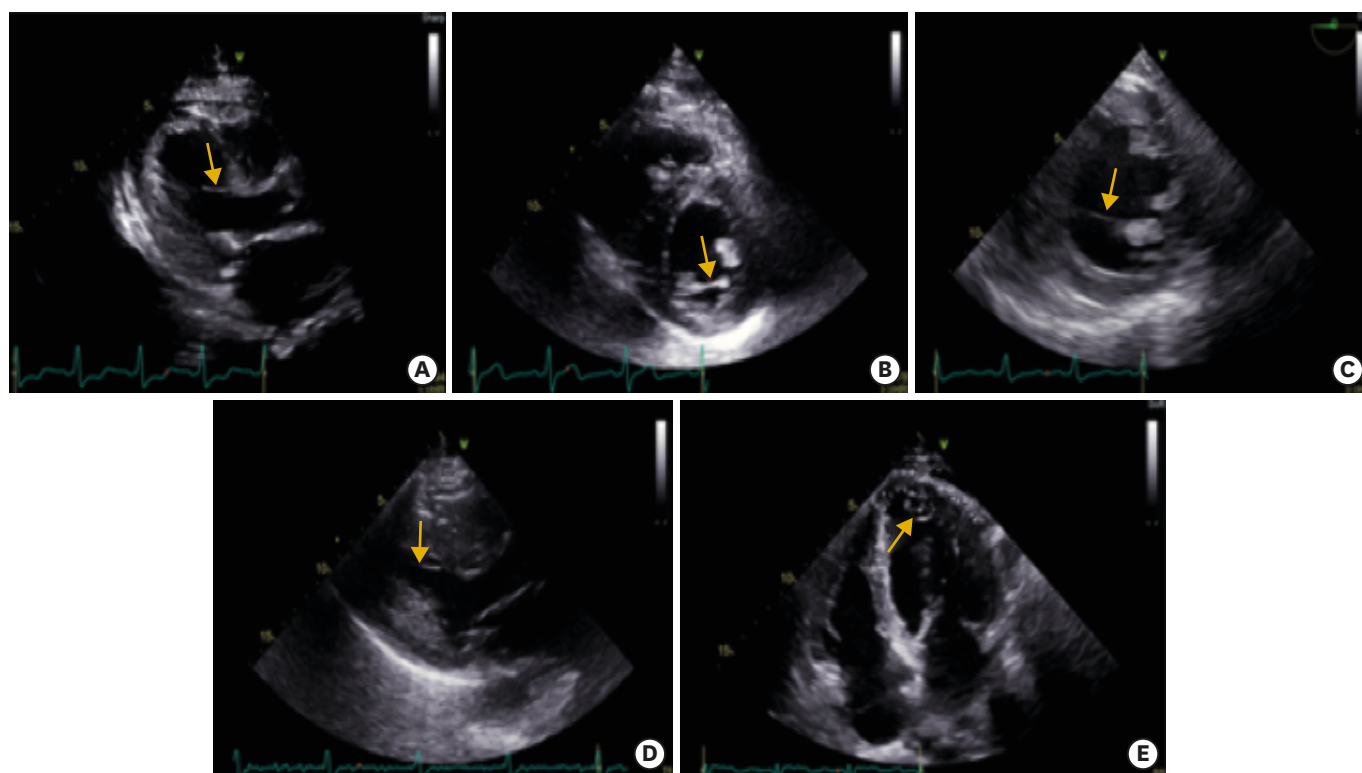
Two-dimensional echocardiographic examples of left ventricular false tendons by specific morphology. (A) Type I posteromedial papillary muscle and basal anteroseptum 7 (21%); (B) Type II anterolateral and posteromedial papillary muscles 1 (3%); (C) Type III anterolateral papillary muscle and basal inferoseptum 1 (3%); (D) Type IV inferoapex and mid anteroseptum 11 (33%); and (E) Type V anteroapex and inferoapex 13 (40%). Note: ‘C’ corresponds to a transesophageal transgastric short-axis view of the left ventricle at the level of the papillary muscle, with the anterolateral papillary muscle located at the 5 o’clock position.
